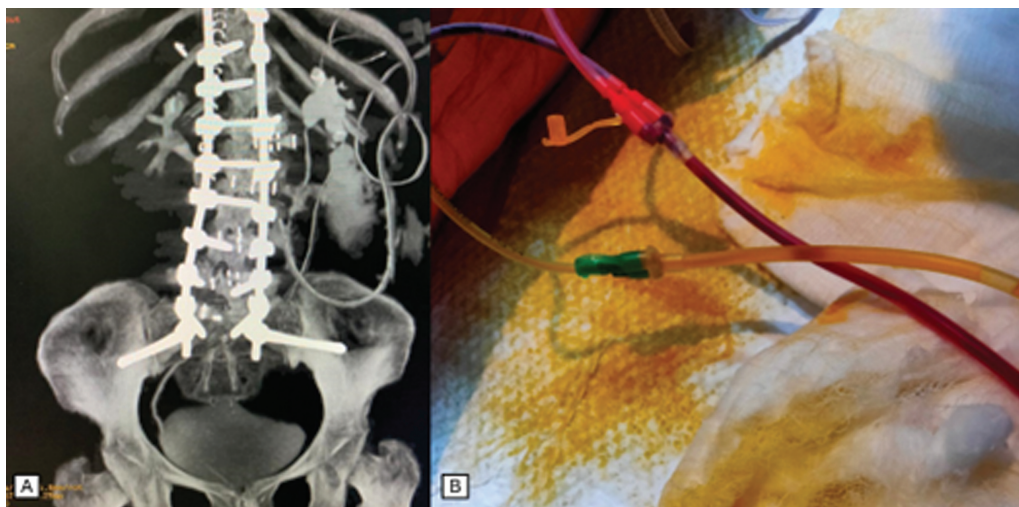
Computed tomography (CT) urography (A) showing nonvisualization of left ureter in a patient who sustained ureteric injury during multilevel oblique lumbar interbody fusion (OLIF). Postoperative clinical images (B) showing separate drainage tubes for the surgical wound and drainage of urine (note the color of the urine due to pyridium tablet) from the ureter. Delayed repair of the ureter was performed after 1 month.
